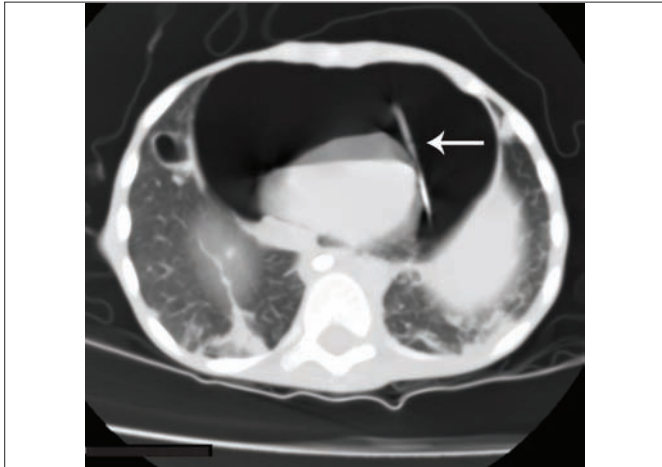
Persistent pneumopericardium on CT scan despite placement of a triple lumen catheter (arrow).
